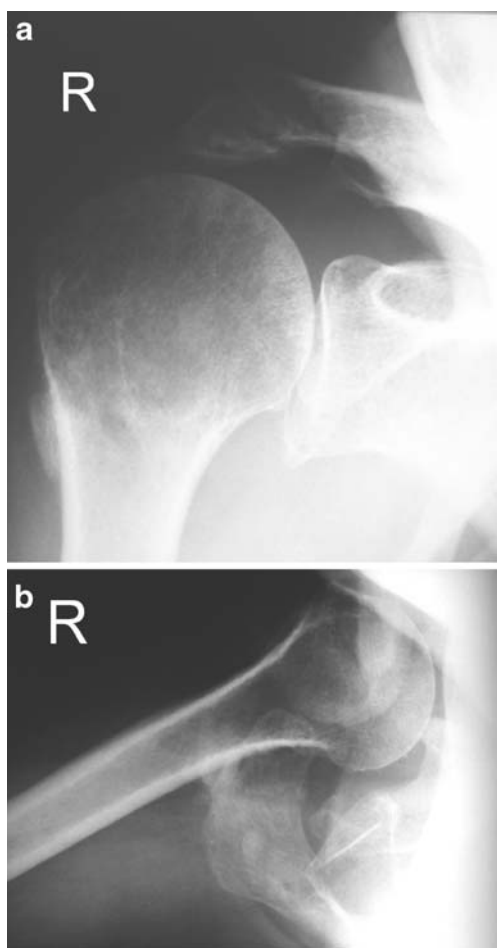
a, b Anteroposterior and axillary radiographs of a 67-year-old woman with a non-reactive type II cuff-deficient shoulder. This patient had undergone a failed reconstruction of the rotator cuff several years previously. In the anteroposterior view the humeral head is decentered and migrated cranially. In the axillary view the humeral head is dislocated anteriorly. There is no narrowing of the joint space or joint incongruity
